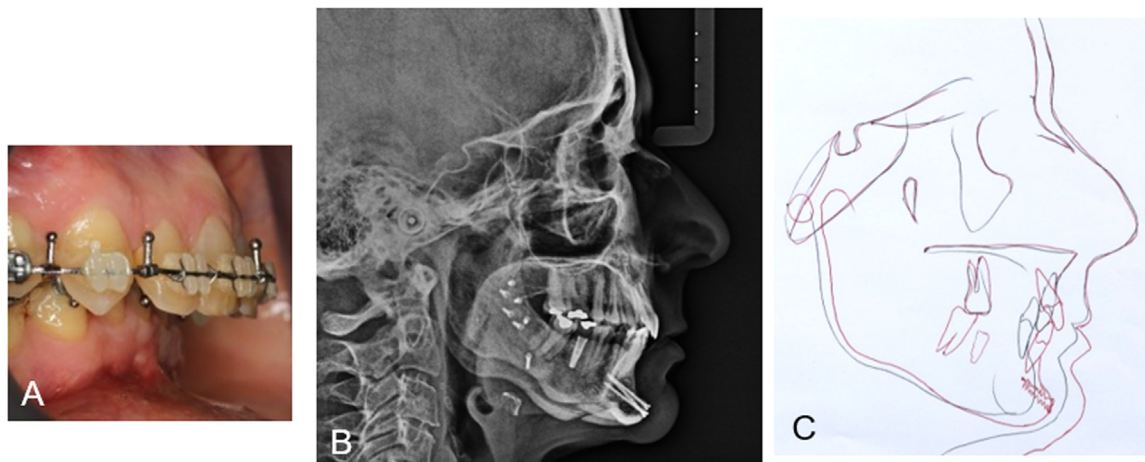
Patient 2. (A), Presurgical intraoral photograph; (B, C), Posttreatment lateral cephalometric radiograph and tracing.
